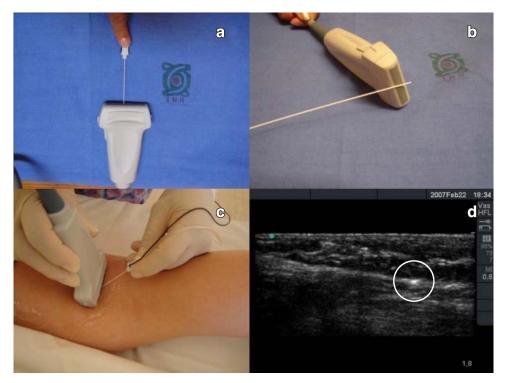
Short axis a y b: Needle advances in cross-sectional from to the transducer, c: Positioning the needle in the short axis *in vivo*, d: Sonographic image of the tip of the needle in the short axis.
